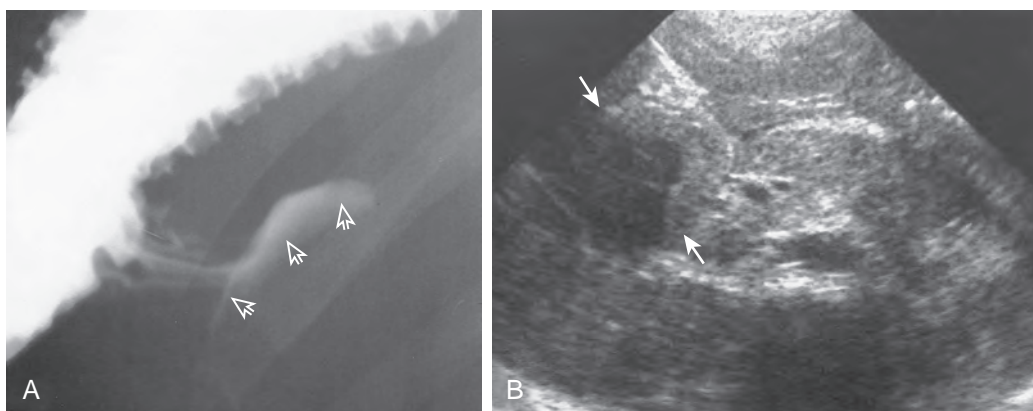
Duodenal hematoma. A. Prone, oblique view from an upper gastrointestinal series shows duodenal obstruction with barium (arrows) outlining a duodenal mass. B. Transverse sonogram of the upper abdomen demonstrates the mass to be a duodenal hematoma (arrows) in this 10-year-old child who sustained a bicycle handlebar injury to the upper abdomen. The complete sonographic study also demonstrated pancreatic swelling and peripancreatic fluid from the injury (not shown).
